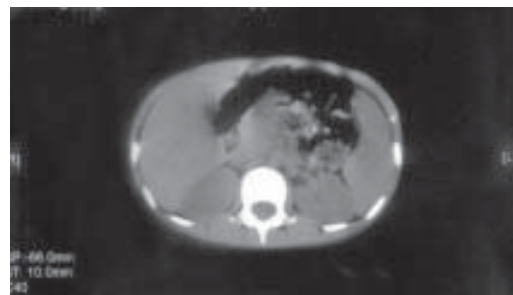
Abdominal computerized tomography examination. Unenhanced CT image showing several low-attenuation lesions diffusely in spleen.
